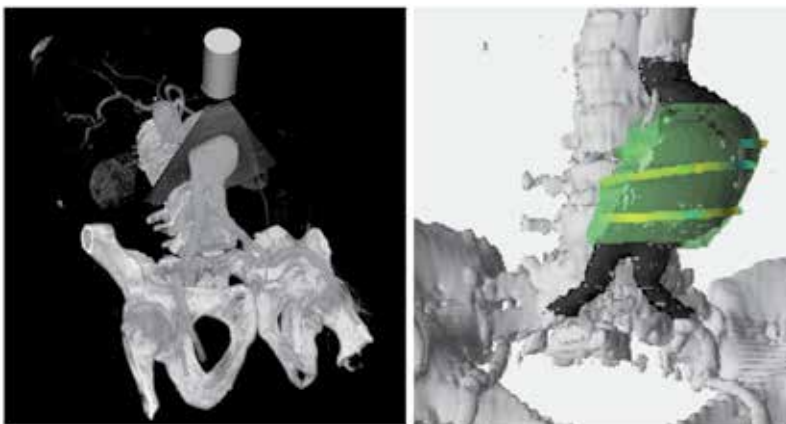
Left: CT and ultrasound in the same scene. Right: 3D visualization of strain. *In Brekken et al. (2007), used with permission.*
